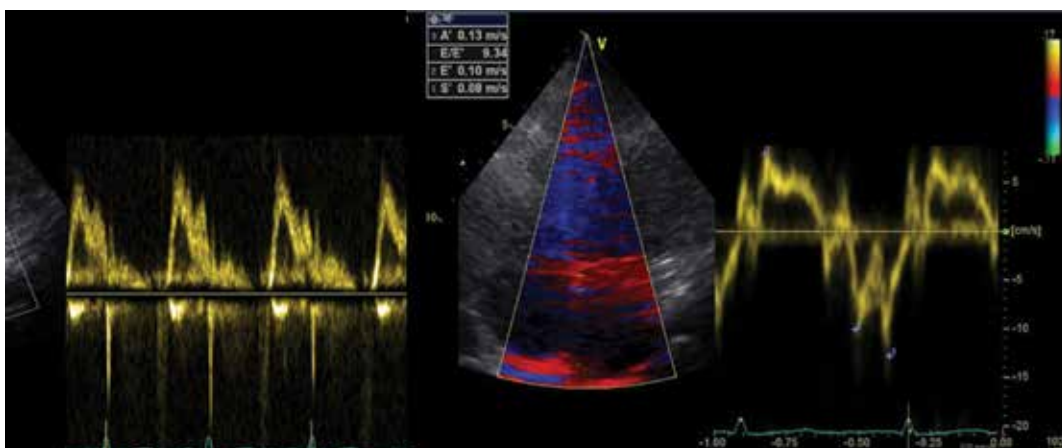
Estimation of Pulmonary Capillary Wedge Pressure from Mitral Doppler E velocity and Tissue Doppler techniques ($PCWP = 1.9 + 1.24 \times E/E'$) or ($E/E' > 15$: $PCWP > 15$ mm Hg)
